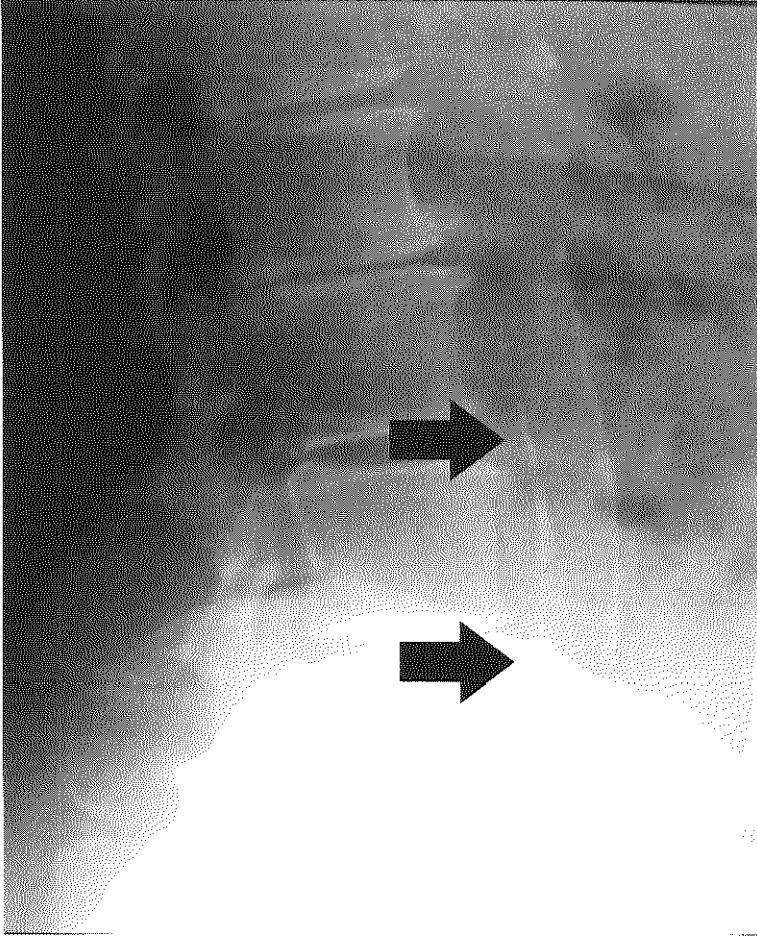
Severe atherosclerosis of the abdominal aorta (arrows) detected on a lateral X-ray of the abdomen
